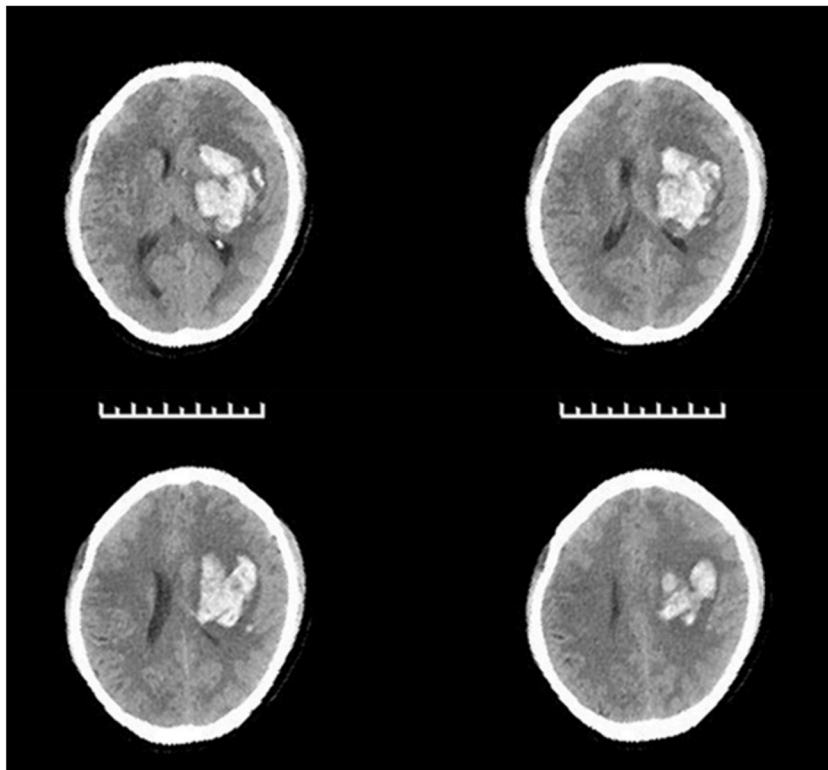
Preoperative CT craniocerebral examination showed cerebral hemorrhage in the left basal ganglia.
